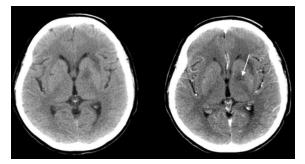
Acute lacunar infarction at genu of the left internal capsule and left gobus pallidus by CT (arrow). Final diagnosis was proved by positive CSF for cryptococcosis. Note old lacunar infarction at right basal ganglion and posterior limb of the right internal capsule
